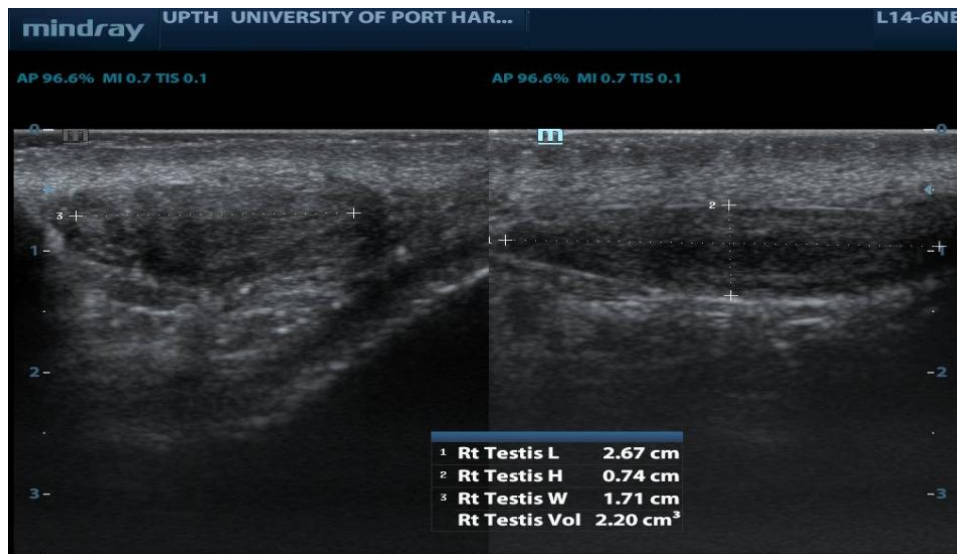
Small testis. Sonogram showing a testis which on measurement had a volume of 2.20 cm³
